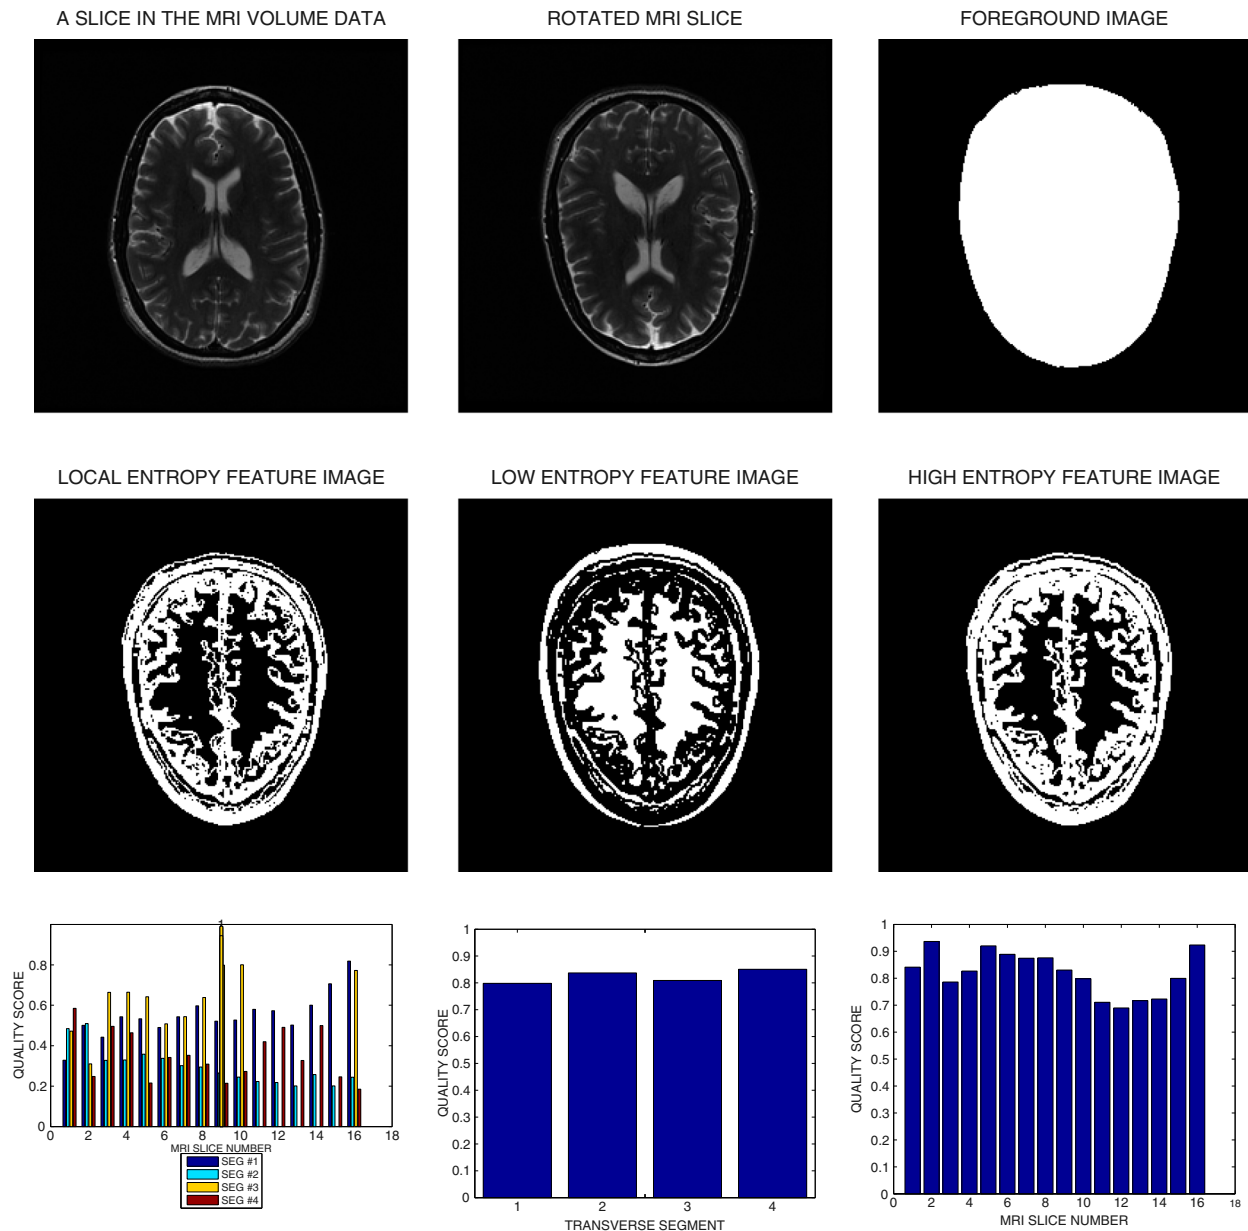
The different stages of post-acquisition quality evaluation for structural brain MRI images. (a) Each slice in the MRI volume data is (b) rotated by 180 degrees to align with the model images in the database. (c) The foreground is extracted followed by (d) filtering to derive the local entropy image. (e) Thresholding the local entropy image extracts (e) the low entropy feature image and the (f) high entropy feature image (g) Whole brain angular segment pixel density (h) Transverse segment pixel density and (i) Whole brain pixel density, quality scores for sixteen successive slices in the MRI volume data.
